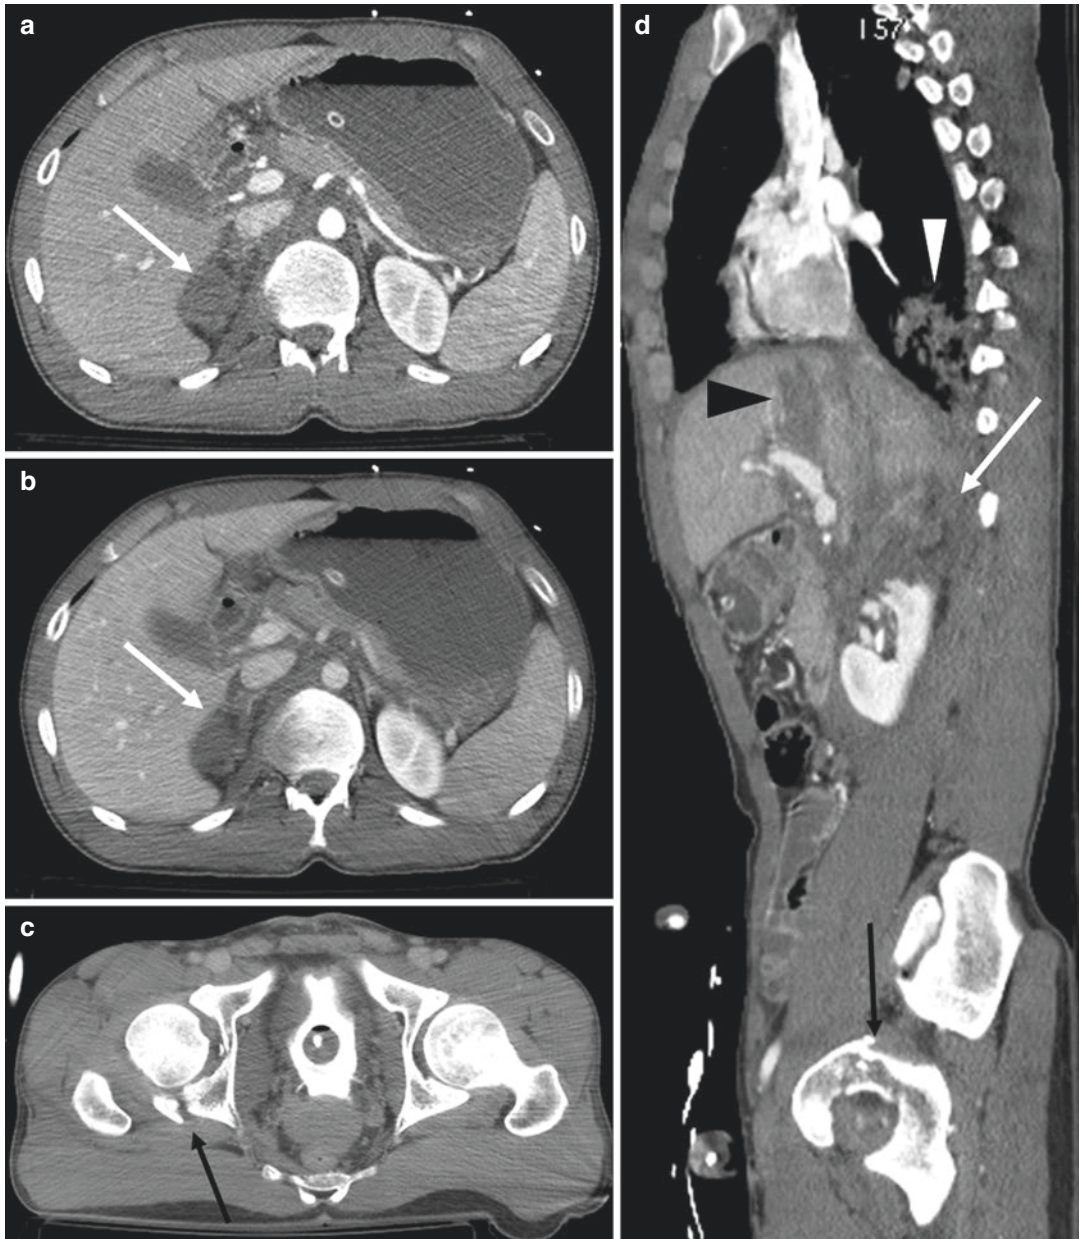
Contrast-enhanced CT. (a, b, and c) Axial scans; (d) sagittal reconstruction. The patient has fallen from height. Adrenal hematoma with associated lesions: axial CT scans show hypodense enlarged adrenal gland (white arrow in a and b); note the presence of associated
